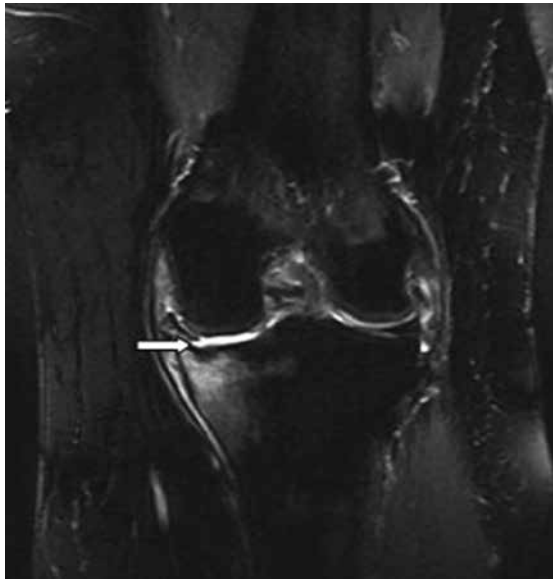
A coronal T2-weighted image with fat saturation showing an osteonecrotic area of low signal intensity (arrow) surrounded by a high-intensity signal caused by edema, compatible with osteonecrosis.
